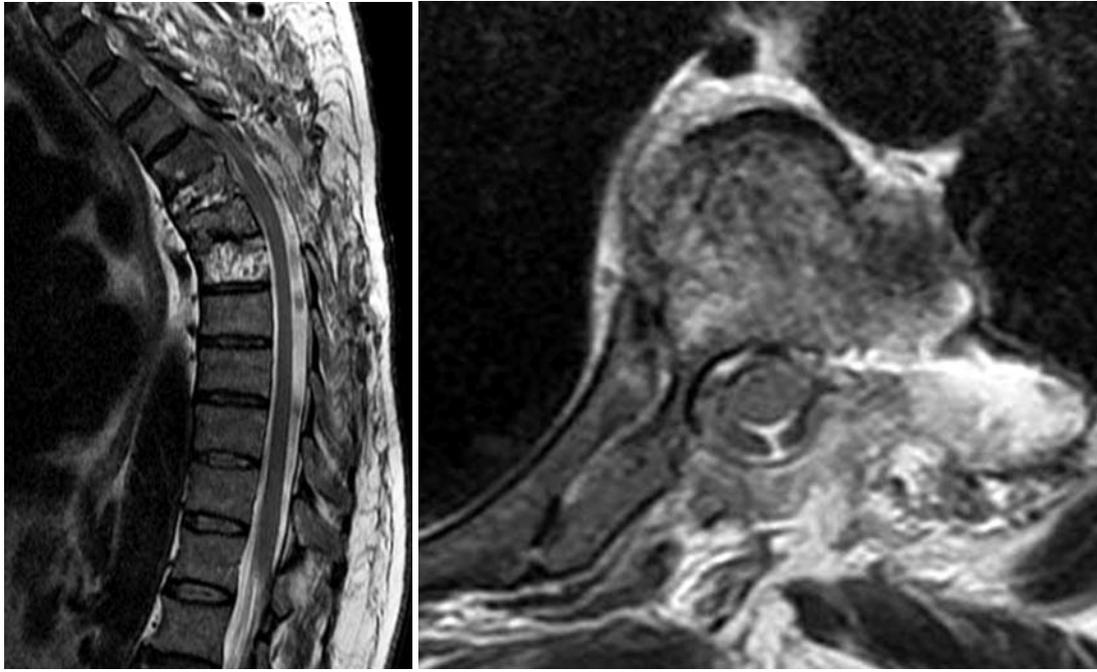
Postoperative (a) sagittal and (b) axial thoracic region MRI images show successful spinal canal decompression
